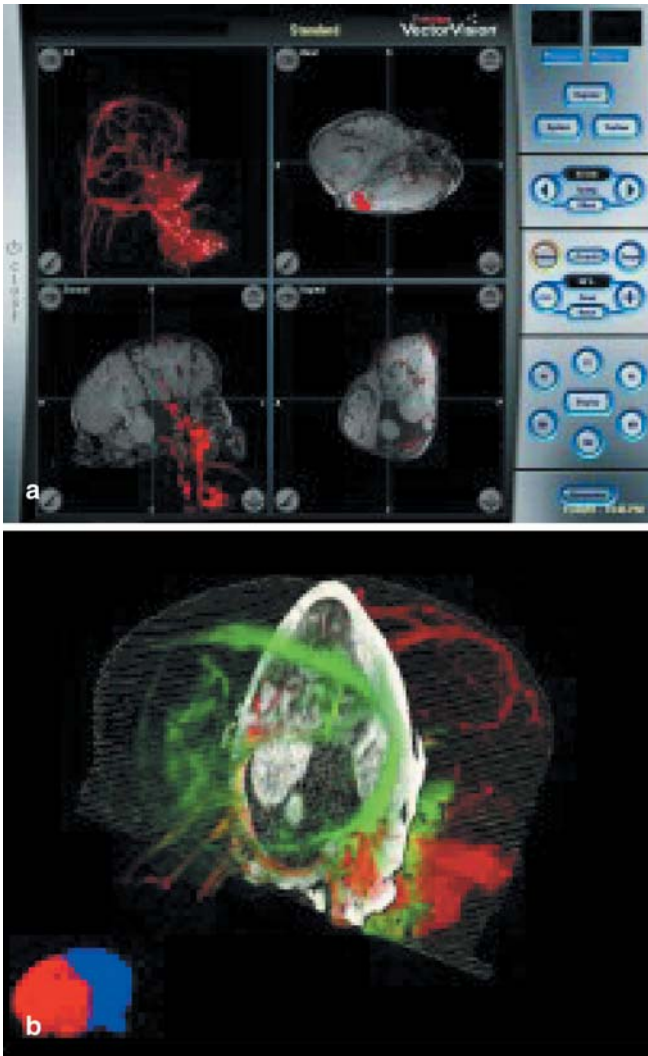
a,b Advanced image analysis and visualization techniques. a 3D-rendered MR angiographic contrast-enhanced venous branches (*red*) can be visualized and manipulated within the anatomical MR-based or CT-based brain structure (BrainLAB, Germany). b Combined rendering of right and left segmented MR angiographic venous blood vessels and a CT slice of the separation plane between the two brains (Dutch Cancer Institute, Amsterdam)
